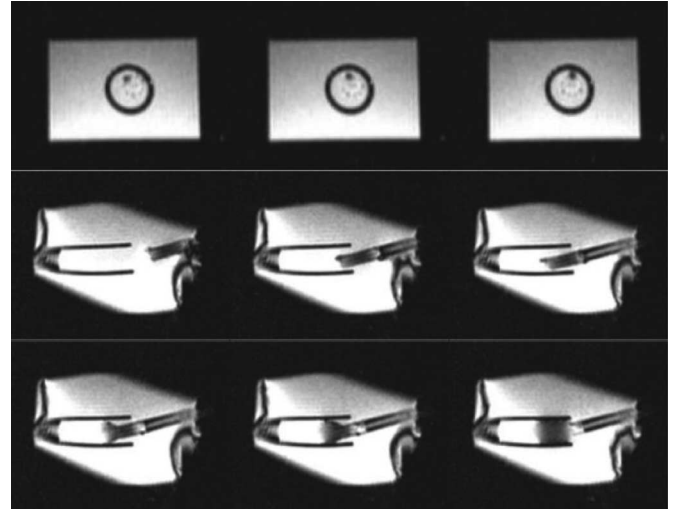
Sequence of MR images showing the progress of using our robotic system to place a prosthesis under MRI guidance. First row shows the orientation adjustment of the prosthesis. Second row shows the position adjustment of the prosthesis. Third row shows the deployment of the SE prosthesis.
